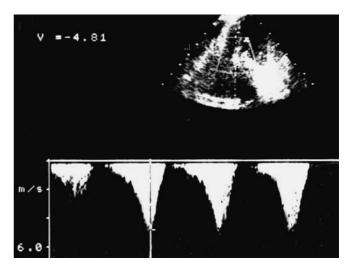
Continuous-wave Doppler shows the characteristic latepeaking high-velocity curve (Vmax=4.81 m/s) due to dynamic left ventricular outflow obstruction. GRADmax=92 mmHg
